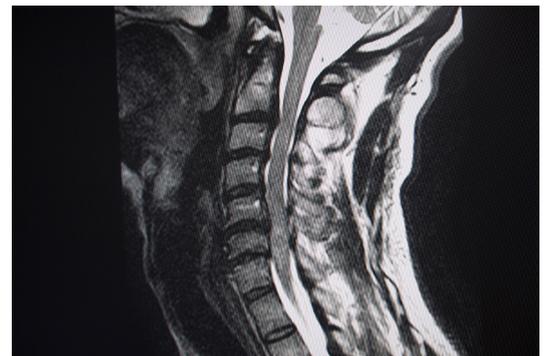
MRI cervical spine revealed severe injuries to the cord. T2-weighted/STIR images showing intramedullary cord hyperintensity extending from C5 to C7 causing cord expansion and cord oedema, posterior disc bulge at intervertebral discs at C2–C6 levels causing multilevel compression of nerve roots.
